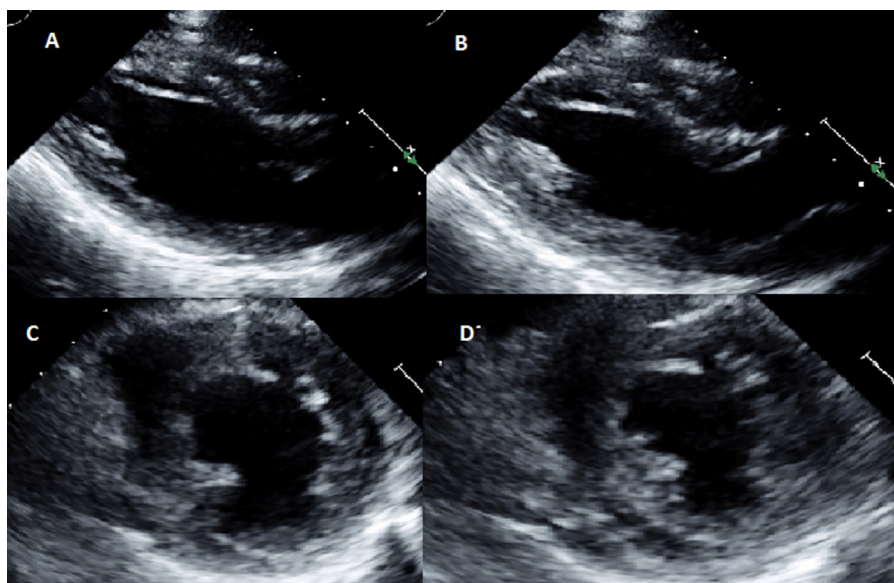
Initial transthoracic echocardiogram showing moderate left ventricular dysfunction. Para-sternal long-axis view during end-diastole (A) and end-systole (B) and para-sternal short-axis views during end-diastole (C) and end-systole (D).
